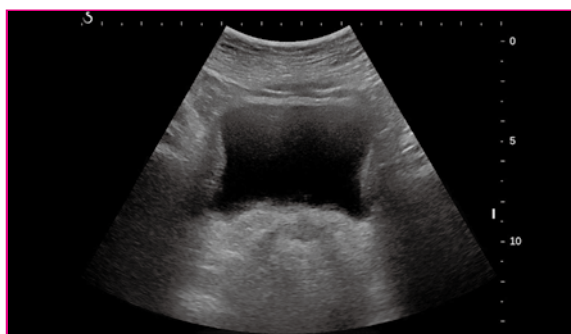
A grey scale ultrasound image shows a transverse scan of a normal filled urinary bladder with well-defined bladder walls. (Personal collection)
